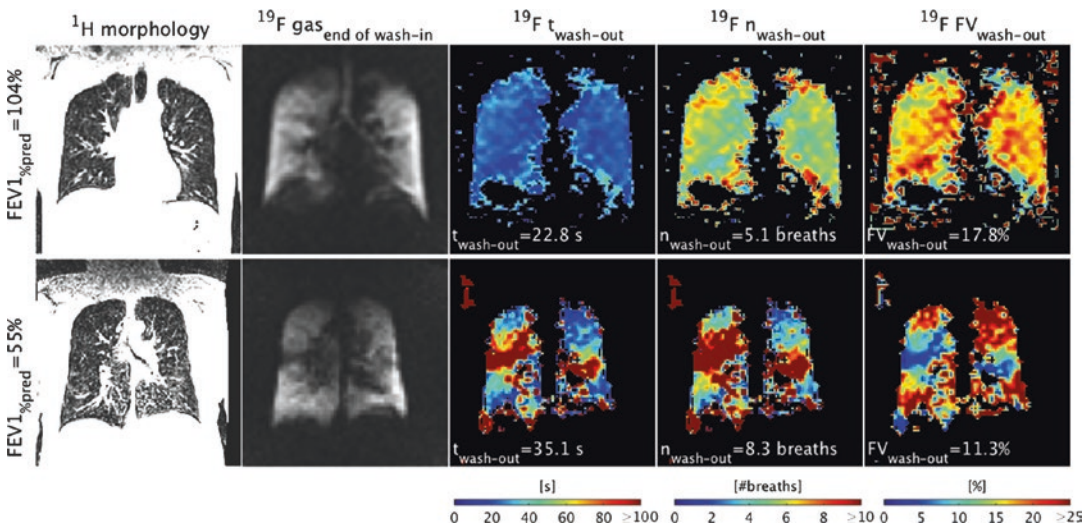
A healthy volunteer (first row) and a COPD patient (second row) examined with ^{19}F gas washout MRI in free breathing. Shown is ^1H MRI (first column), ^{19}F gas MRI directly before starting the ^{19}F gas washout (second column), washout time maps in units of seconds ($t_{\text{wash-out}}$, third
